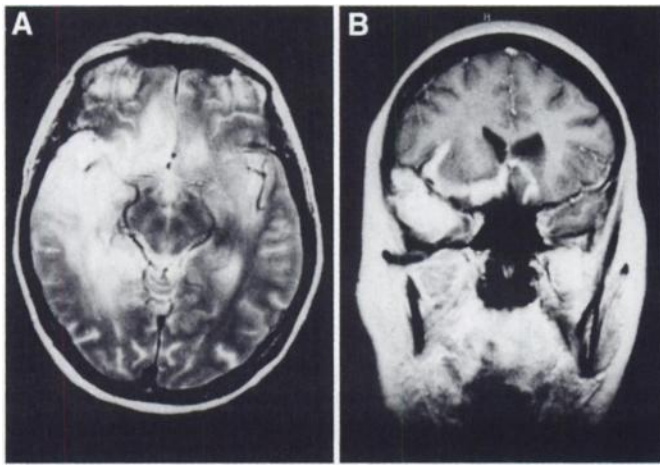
T2-weighted MR images of Patient 2. Signal hyperintensity in right temporal lobe is congruent with increased uptake of ^{99m}Tc -HMPAO and decreased uptake of ^{99m}Tc -ECD (Figs. 1 and 2, respectively).
